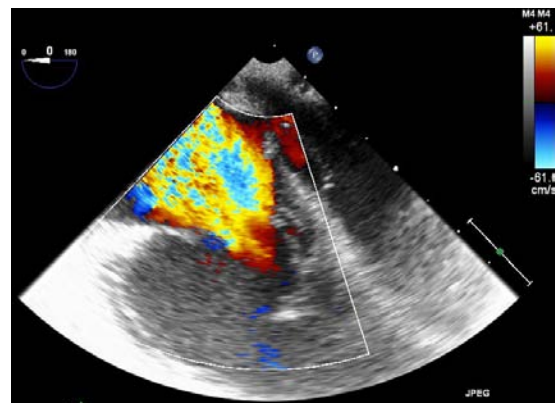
Severe tricuspid regurgitation on color flow Doppler (103)
